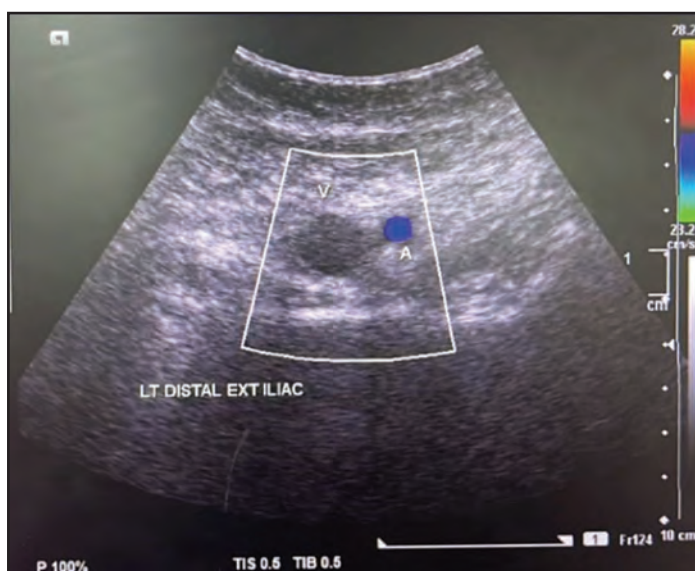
Colour doppler flow not seen within visualised left distal external iliac vein with presence of echogenic thrombus within.
